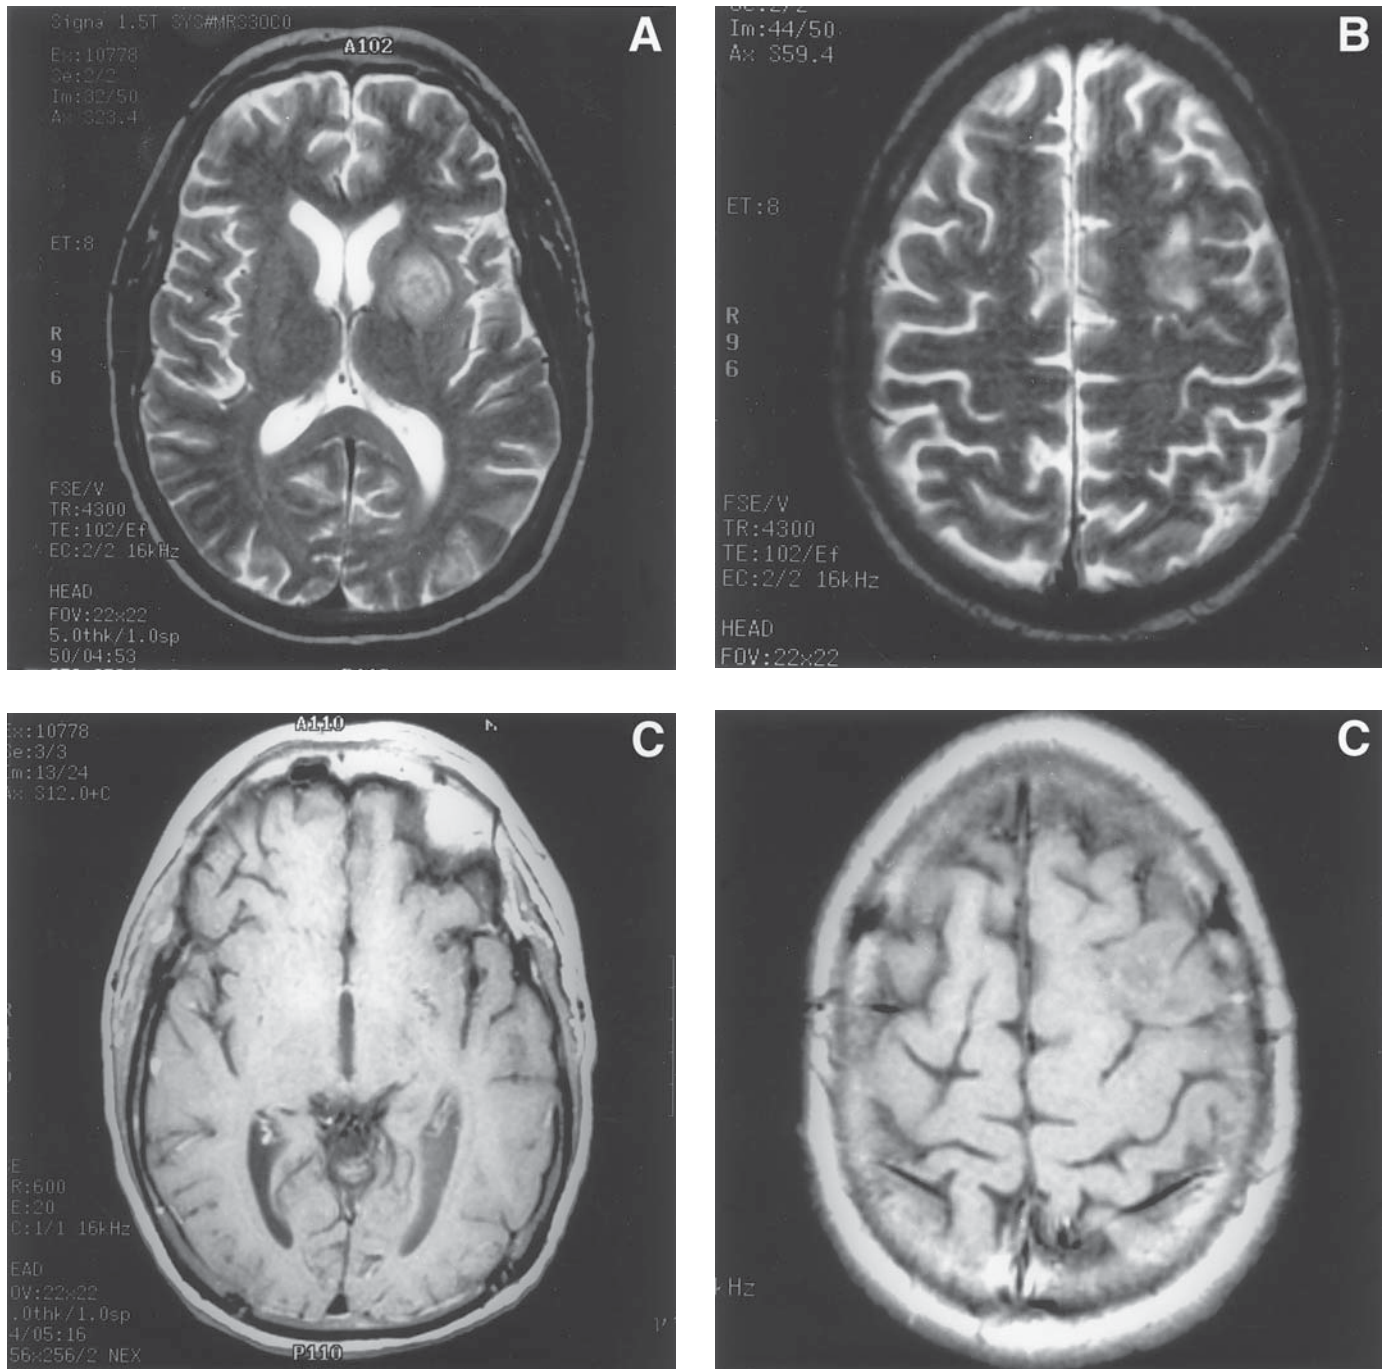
Axial MRI, T2 weighted (A and B) and T1-weighted post-gadolinium (C and D) of *Aspergillus flavus* lesions in the brain of a 31-year-old male 10 mo after allogeneic bone marrow transplantation for AML. He was admitted 1 mo prior to death with respiratory insufficiency, and developed generalized tonic-clonic seizures 2 wk later. Autopsy confirmed the presence of *A. flavus* from a right temporal lesion. Note the very faint enhancement of the left basal ganglia and left frontal lesions.
